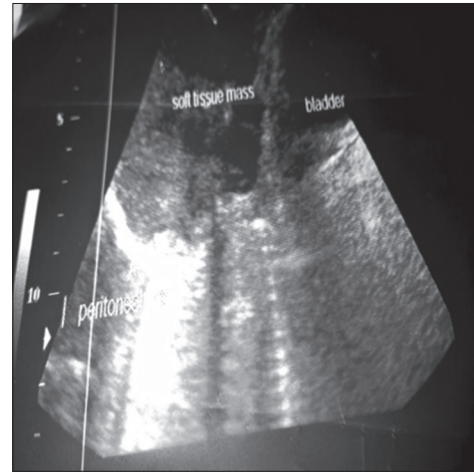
The abdominal ultrasound scan
